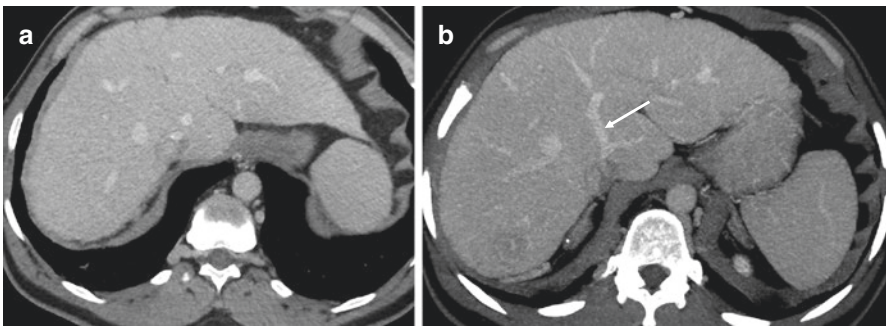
Chronic form of Budd–Chiari syndrome in a 36-year-old female patient with paroxysmal nocturnal hemoglobinuria initially mistaken for cirrhosis. Contrast-enhanced CT (portal venous phase) showed a dysmorphic liver with lobulated contours. Hepatic veins were paradoxically patent due to the peculiar cause of the disease (a). Yet, segment 4 was not atrophied and intrahepatic collaterals were visible (arrow), which is unusual in cirrhotic patients (b)
